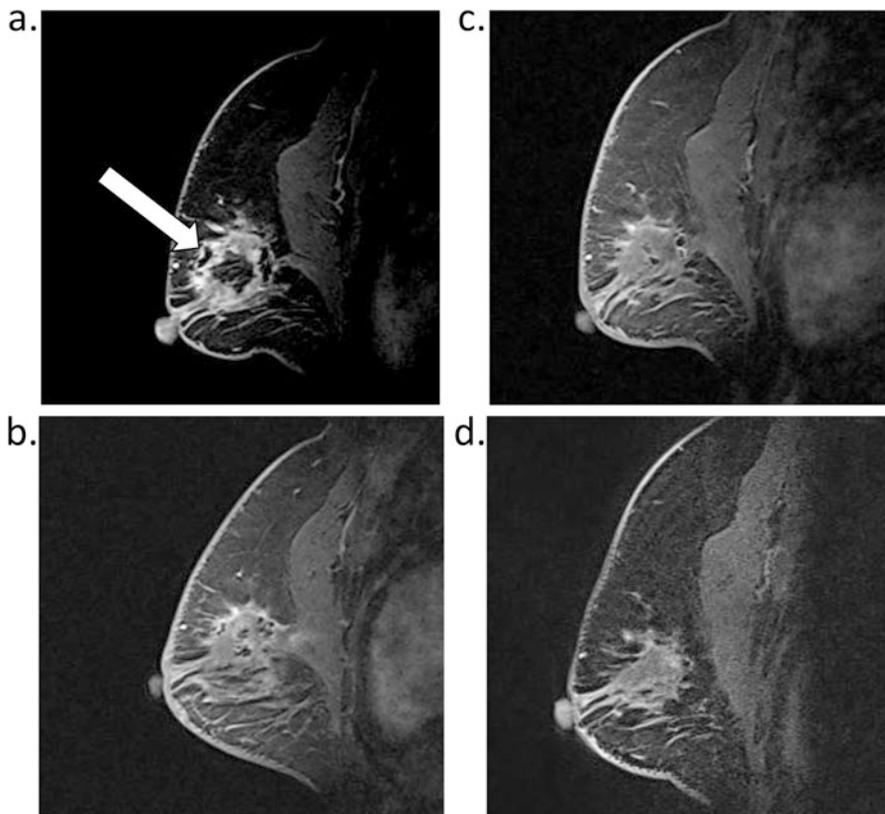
Serial changes of breast MRI after cryoablation. (a) One month after: peripheral enhancement around the granulation was noted (*white arrow*). (b) Six months after: peripheral enhancement subsided. (c) Eleven months after. (d) Thirty-three months after: peripheral enhancement was diminished. Granulation was smaller than before
